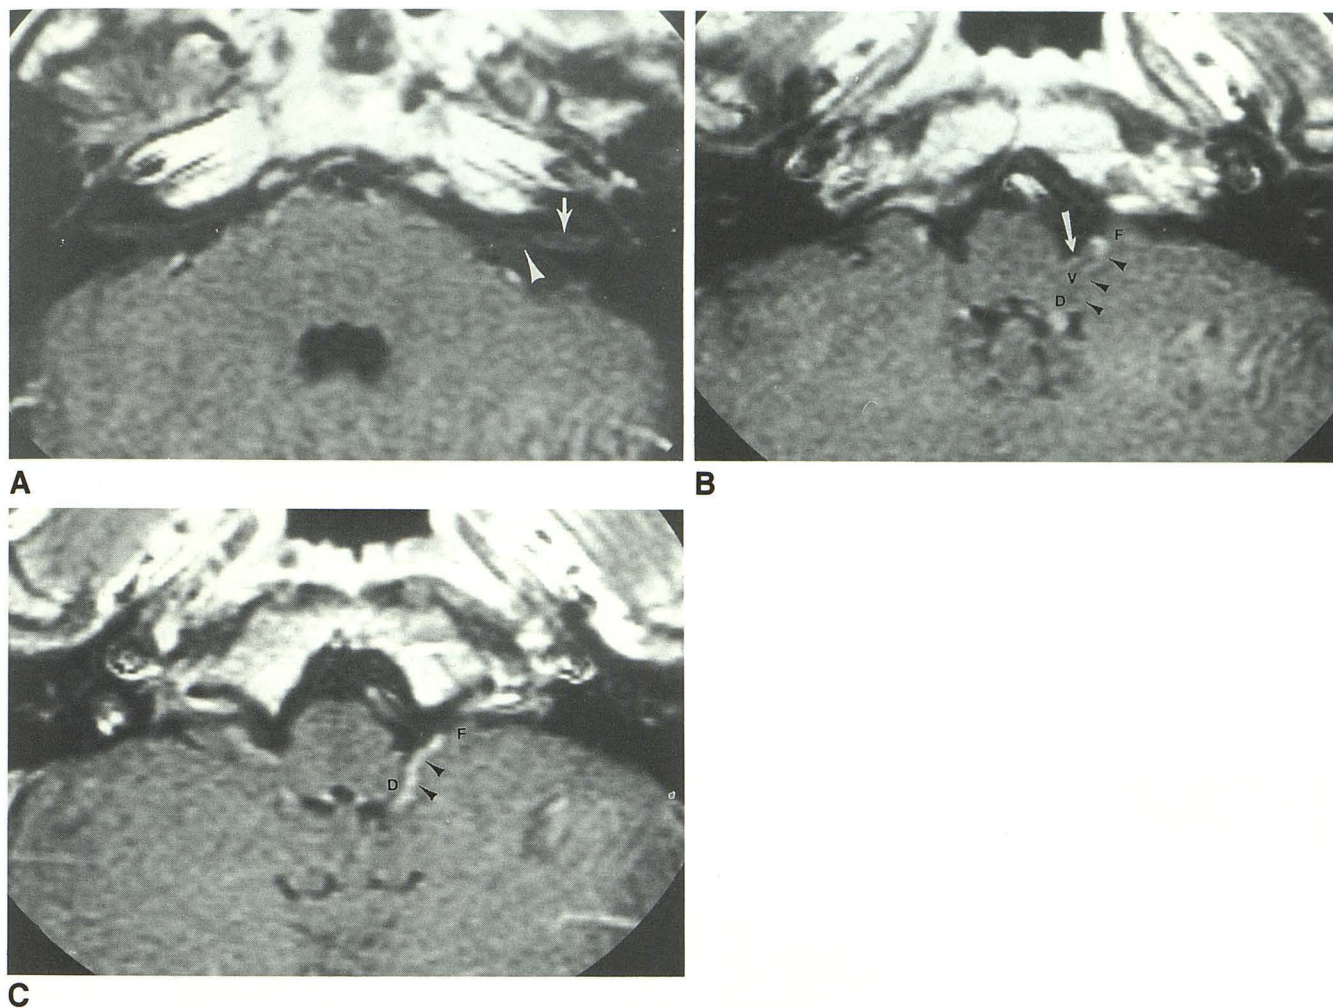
A, Axial MR image (1.5 T, 567/20, 3-mm section thickness) after intravenous infusion of 0.1 mmol/kg of gadopentetate dimeglumine. Inferior orbitomeatal plane of section. Canalicular (*arrow*) and cisternal (*arrowhead*) portions of CN 8 are shown on the *left*. CN 8 descends through the cerebellopontine angle cistern toward the brain stem. No portion of the foramen of Luschka shows on this section.
